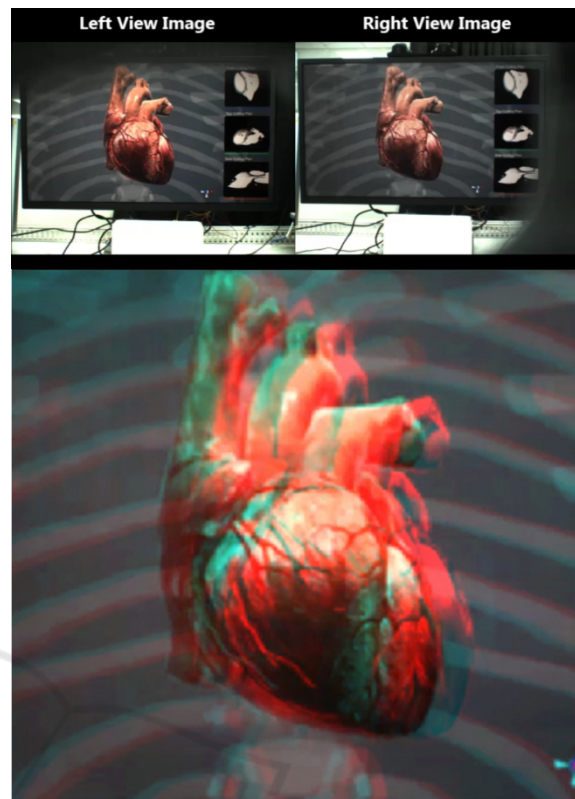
Stereo images from 3D mesh for a 3D CT volume (up) and generated anaglyph (down). A graphics artist decorated the heart manually.
